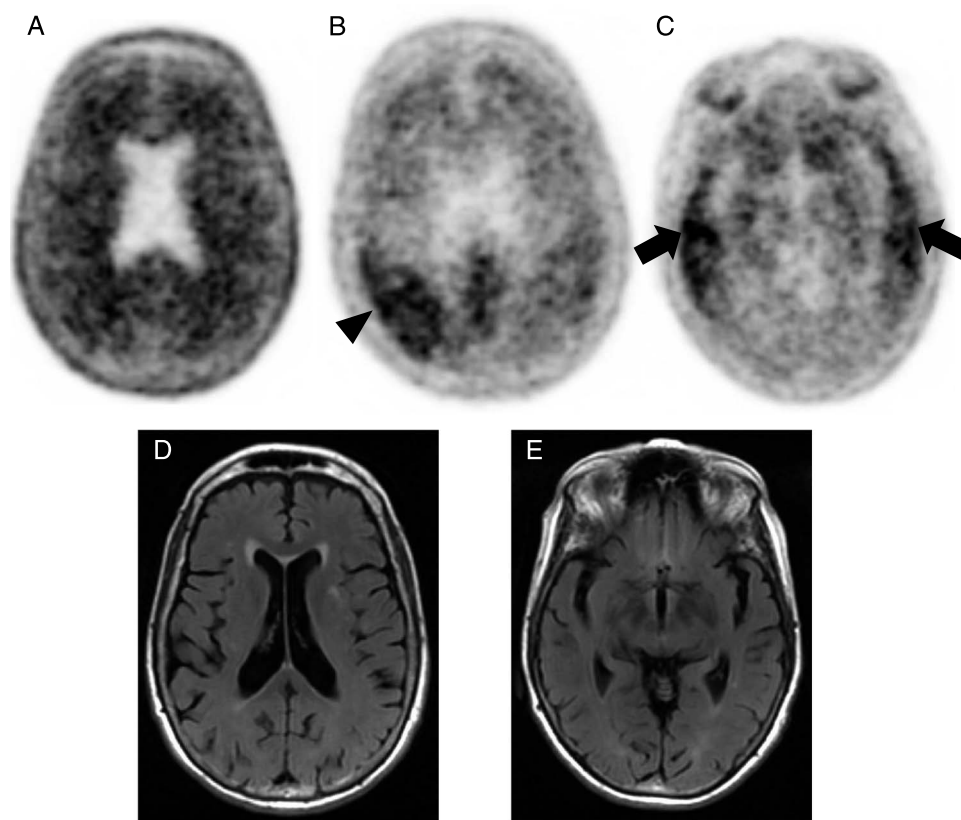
Positive amyloid and tau scans. This 70-year-old man has a 4-year history of memory impairment and a strong family history of Alzheimer disease (AD). Florbetapir-PET (A) shows loss of gray/white matter differentiation. His flortaucipir-PET (B) shows symmetric bilateral intense parietal lobe accumulation (arrows) typical for AD.<sup>7</sup> MRI (C) was normal for age. He received cholinesterase inhibitor therapy. He progressed over 4 years to advanced dementia. Flortaucipir-PET has a sensitivity of 89.9% and specificity of 90.6% for discriminating AD from other neurodegenerative diseases.<sup>8</sup>
